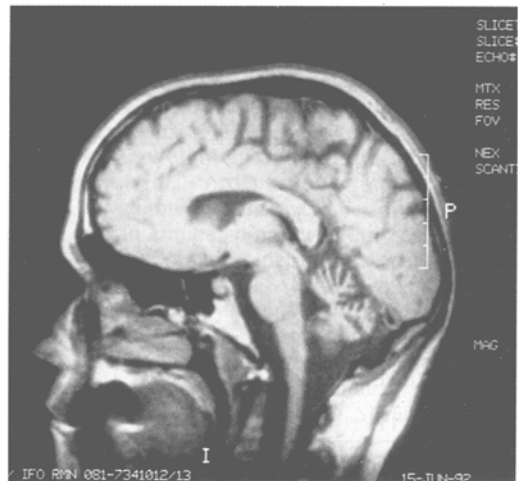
T1-weighted spin-echo sequence (0.5 T) in the middle sagittal plane in an LOFD patient (No. 15) showing moderate vermian atrophy and slight fourth ventricle enlargement.
